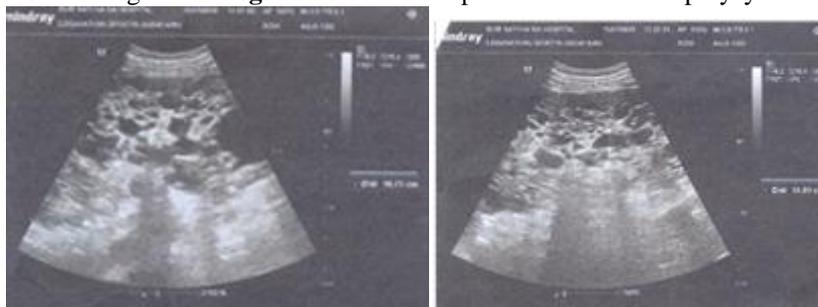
Ultrasonogram.of Jayasurya showing bilateral polycystic kidney
